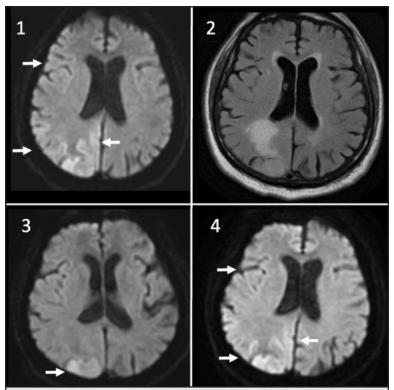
MRI DWI at presentation with altered mental status, showing cortical restricted diffusion in the right parietal-temporal-occipital lobes (arrows).
